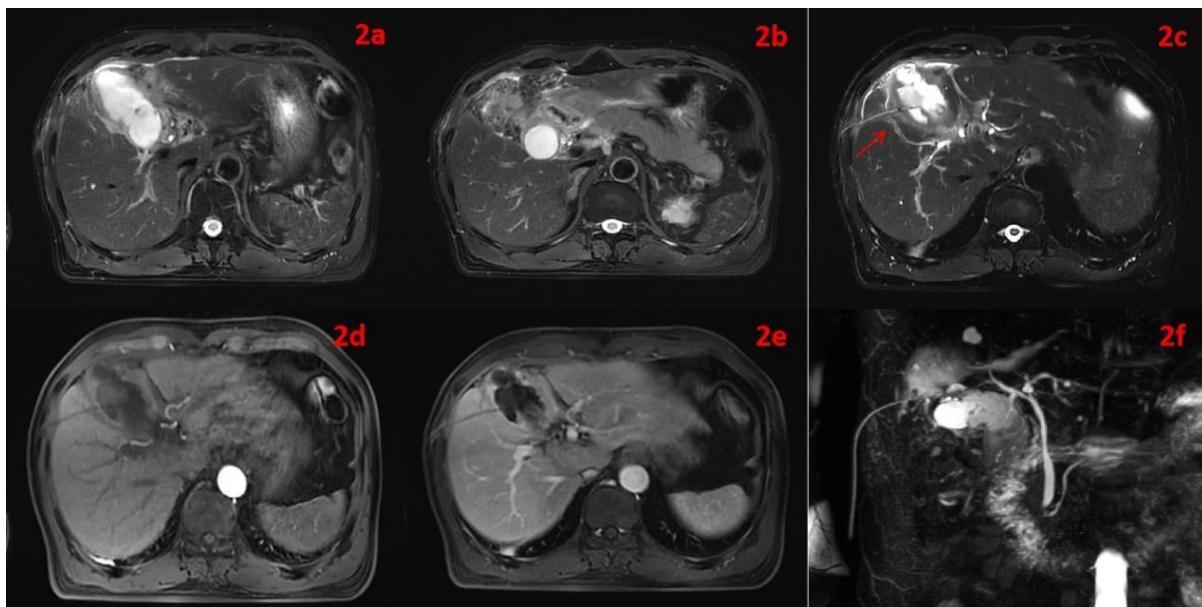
(2a) MRI T2-weighted imaging revealed chronic inflammatory changes in the gallbladder. (2b) The gallbladder was densely adherent to the surrounding tissues. (2c) The gallbladder puncture drainage tube traversed the terminal portion of the segment V hepatic pedicle (arrow). (2d-2f) No significant abnormalities were noted in the remaining arterial phase, portal venous phase, or MRCP.
